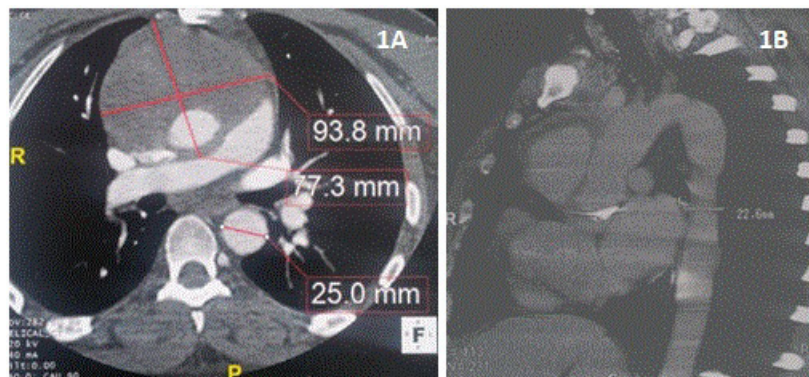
CT scan of the thoracic aorta showing a formation of the ascending aorta of 93×77 mm, consistent with a partially thrombosed false aneurysm
